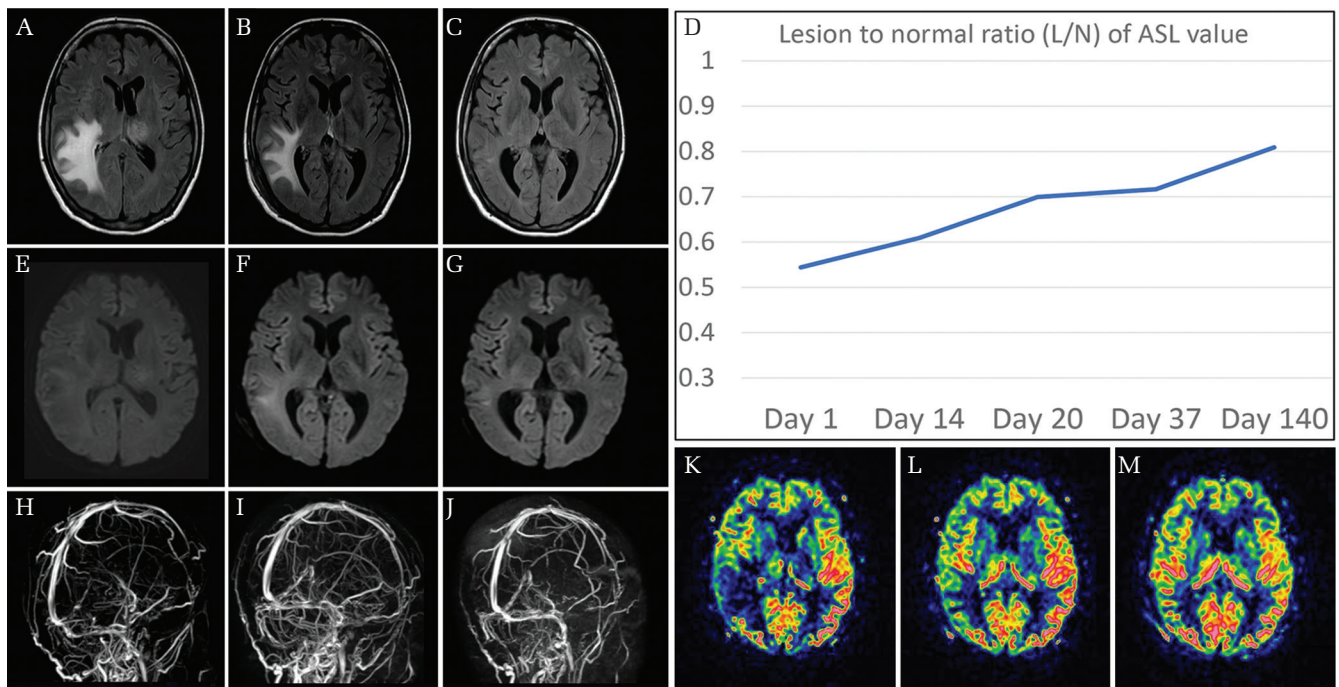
The sequential change of the MRV, ASL, FLAIR, and DWI for patient with right transverse sinus occlusion. While DWI (E) showed slight hyper-intensity in the right temporal lesion, FLAIR imaging (A) demonstrated marked elevation in the affected area. Faint signal of right transverse sinus and straight sinus by MRV (H), with decreased ASL at the right temporal cortex can be seen at Day 1 (K). While the development of venous collateral is partial, improvement of ASL, FLAIR, DWI can be found at Day 14 (B, F, I, L). Further recovery of venous collateral and other parameters can be seen at Day 140 (C, G, J, M). The graph shows the serial change of the ASL signal by lesion to normal ratio (L/N) (D).
